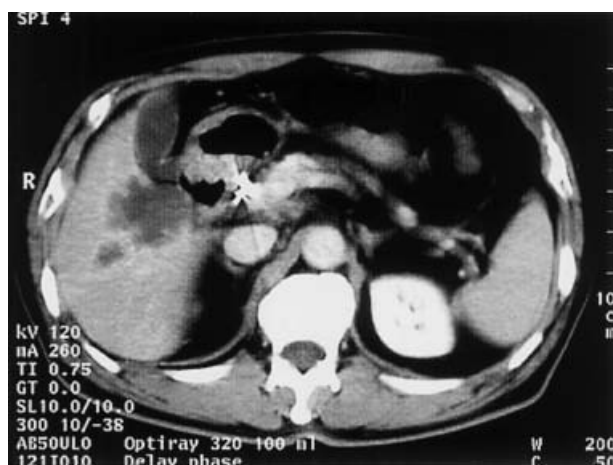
CE-CT revealed decrease of liver metastases in number and size after 14 days administration.
